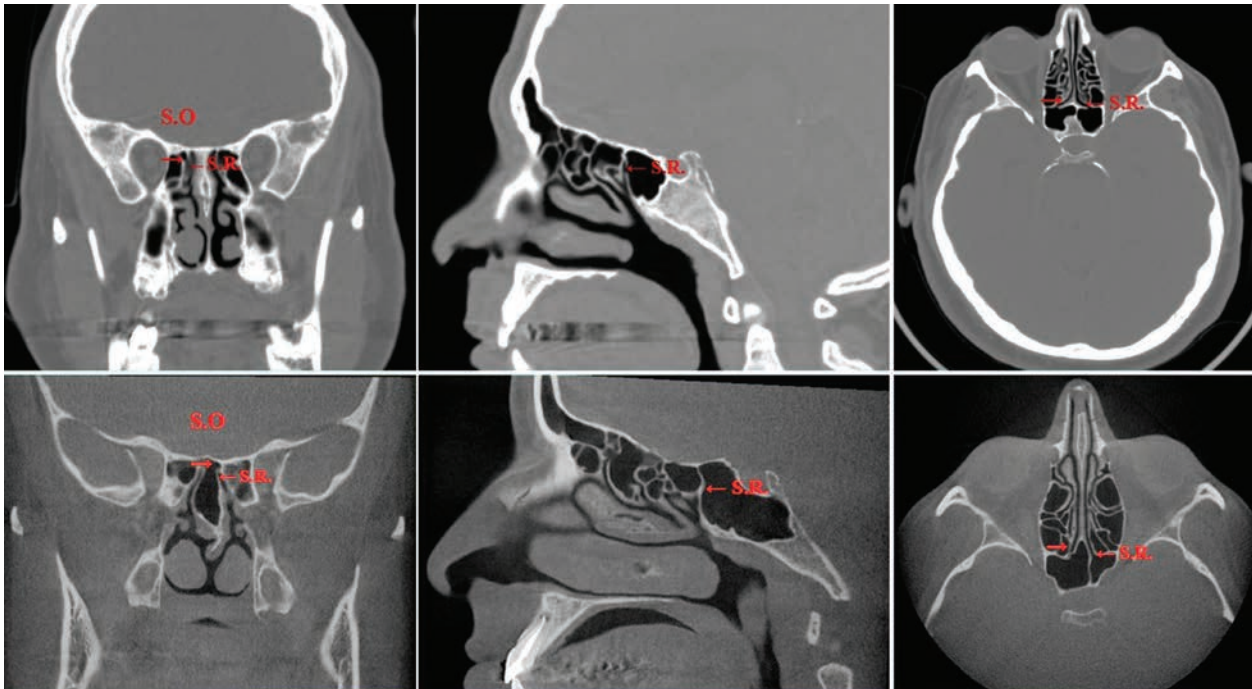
Coronal, sagittal and axial sections of standart-CT (up) and CBCT views of sphenoidal recess including sphenoid ostium.
